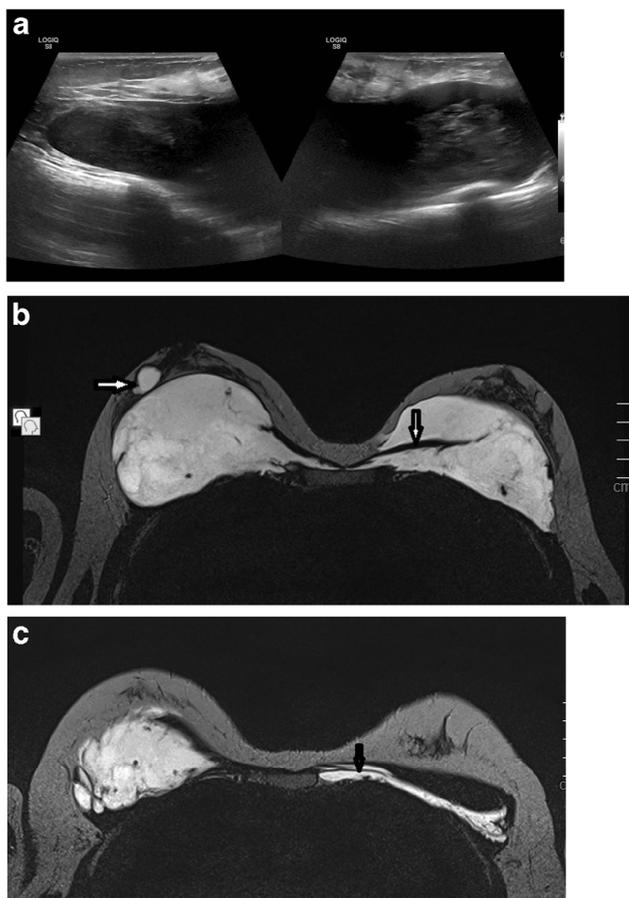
28-year-old female. a Complex cystic structure with multiple mobile hypoechoic inner foci is noted on US in the retroglandular area of the right breast. Non-fat sat high-resolution T2-W axial MRI (b, c)
